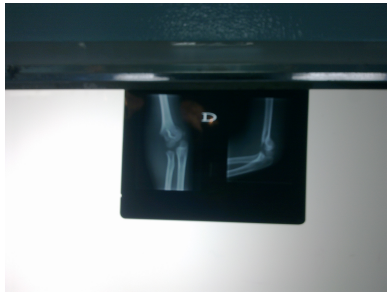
The fracture's radiographs.
